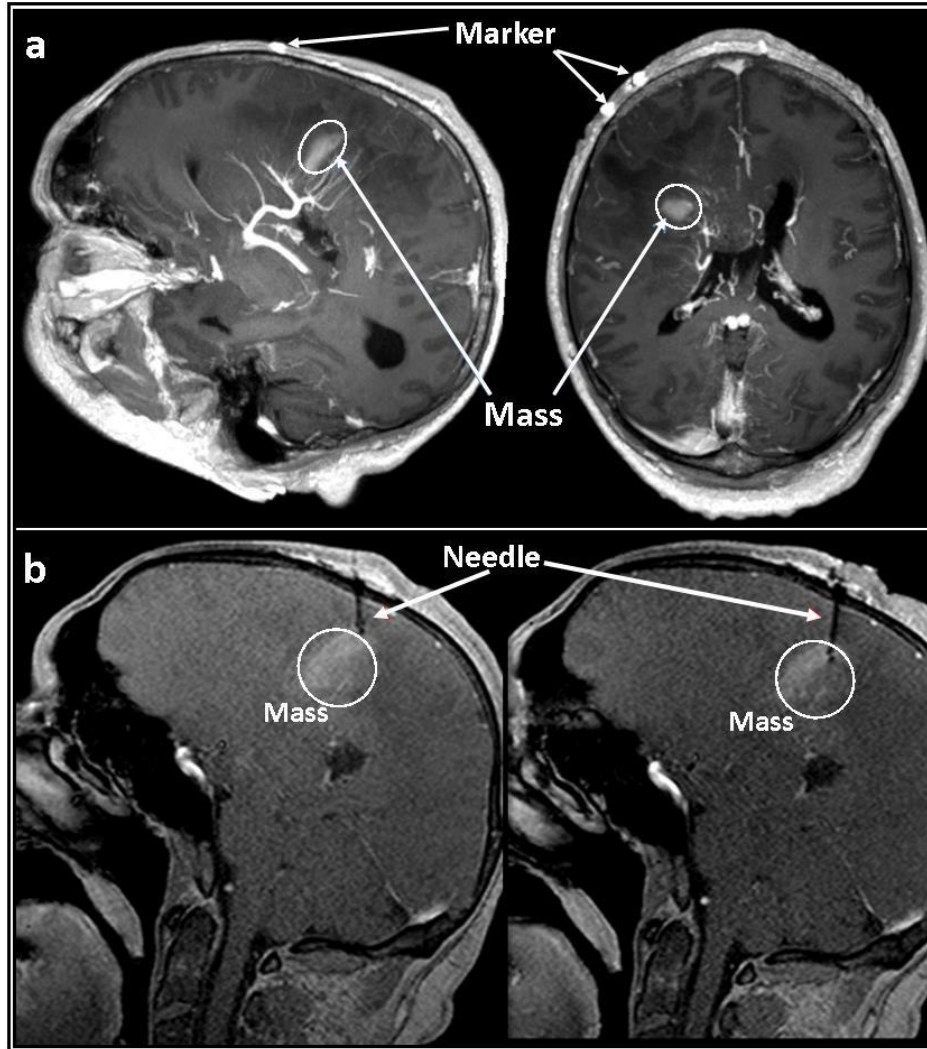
Clinical feasibility of biopsy needle guidance using resonator markers under 3T MRI scanner. An array of markers ( $2 \times 2$ ) was fixed on a patient head included a mass. (a): The position of the mass with respect to the markers is clearly indicated on  $T_1$ -weighted GRE images. (b): After graphically marking the positions of the markers and needle insertion point, the needle insertion procedure was conducted gradually.  $T_1$ -weighted GRE images show the position of the biopsy needle inside the brain close to the mass.
